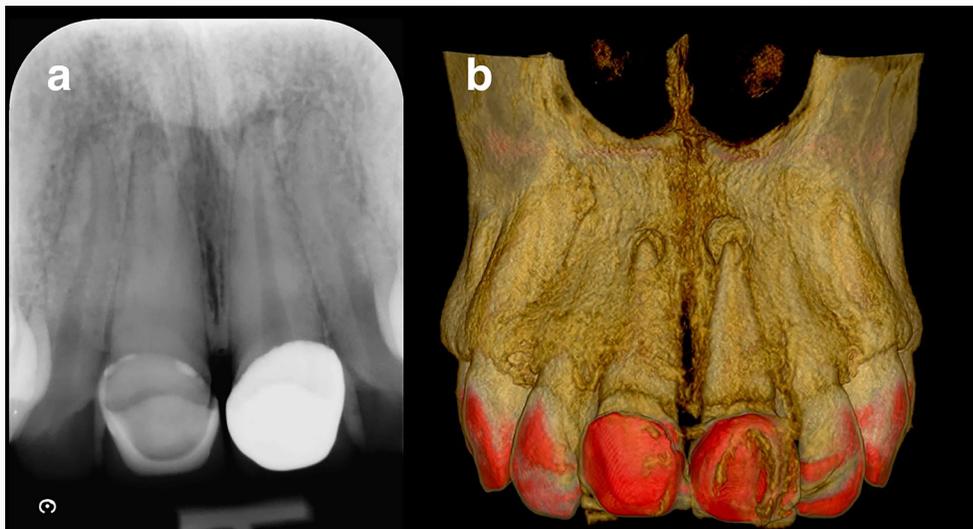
a.) Periapical radiolucencies in both upper central incisors and a severe pulp calcification in tooth 1.1. b.) 3D reconstruction of the volume acquisition
